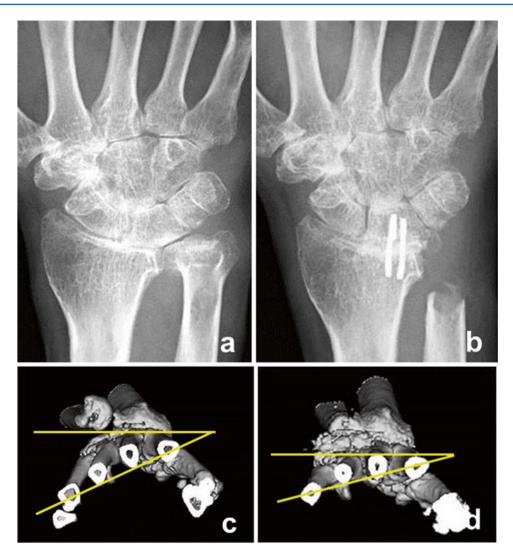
Radiolunate (RL) fusion and Darrach procedure. (a) Preoperative radiograph. (b) Postoperative radiograph. (c) Preoperative 3DCT. (d) Postoperative 3DCT.
